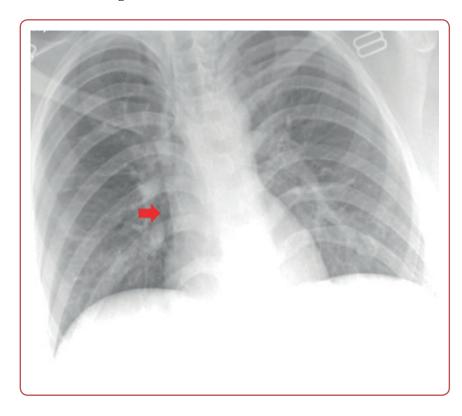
Chest posterior-anterior (PA) X-ray showing linear lucency (arrow) involving the mediastinum and right heart border concerning pneumomediastinum
